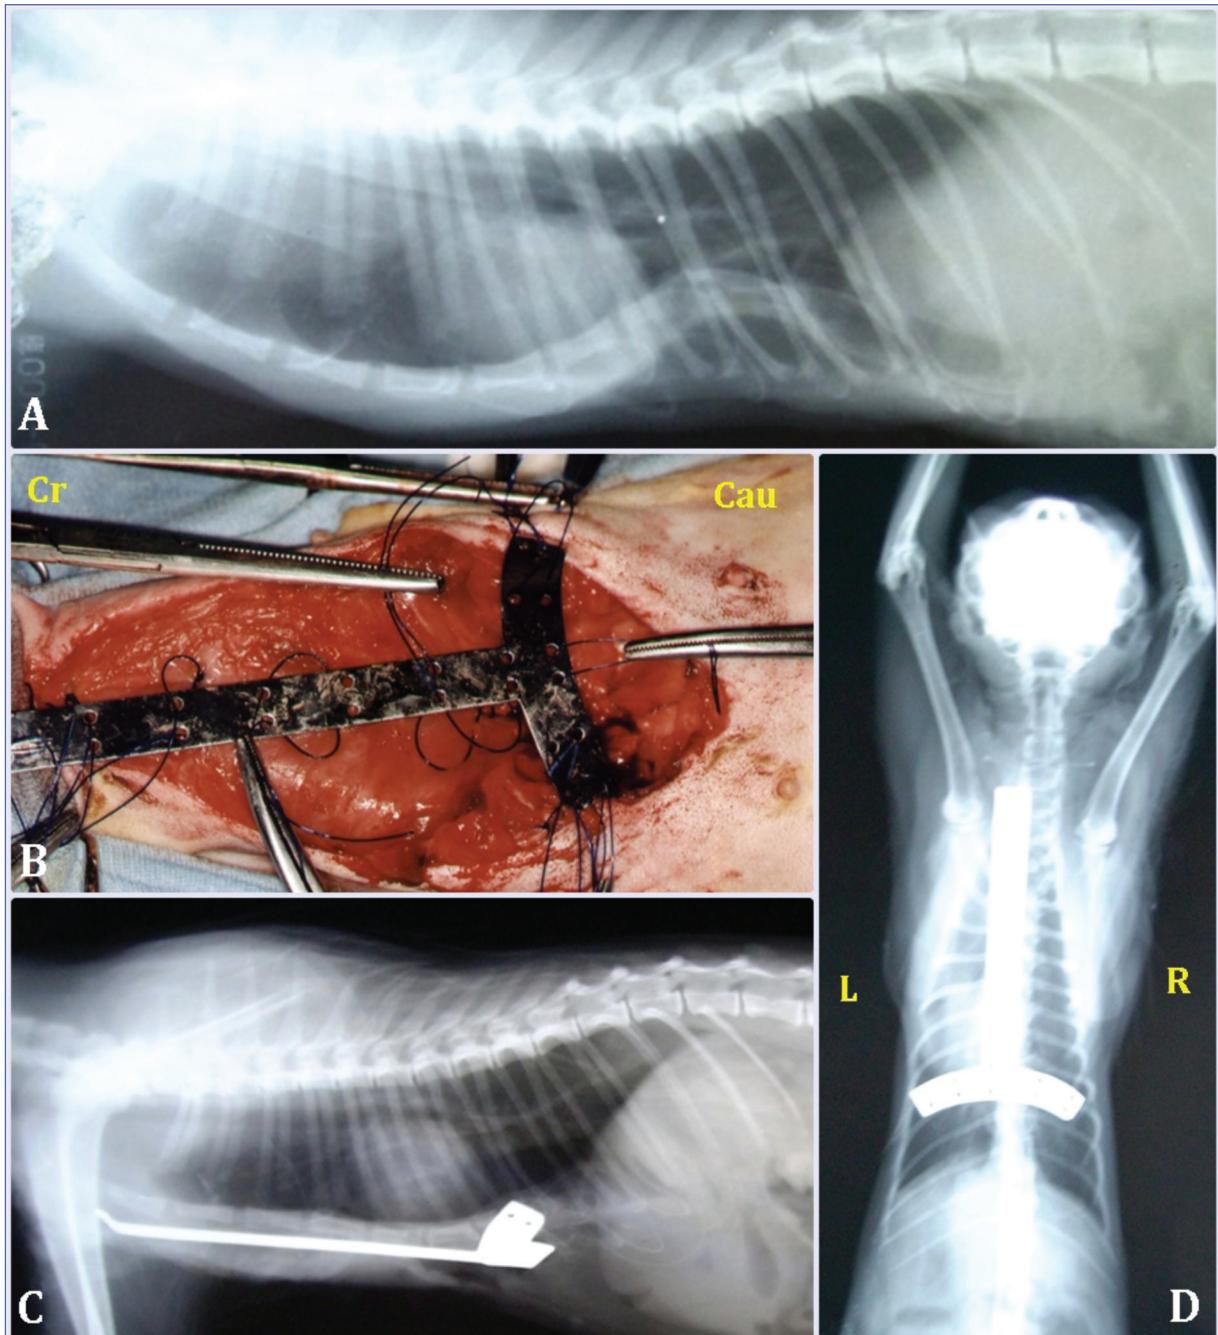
Internal splint application, case no 2. Preoperative lateral radiographic view, A; Placement of internal splint to ventral thorax by circumcostal and circumsternal sutures, B; Postoperative lateral radiographic view, C; Postoperative dorsoventral radiographic view, D; Cr, cranial; Cau, caudal; L, left; R, right
